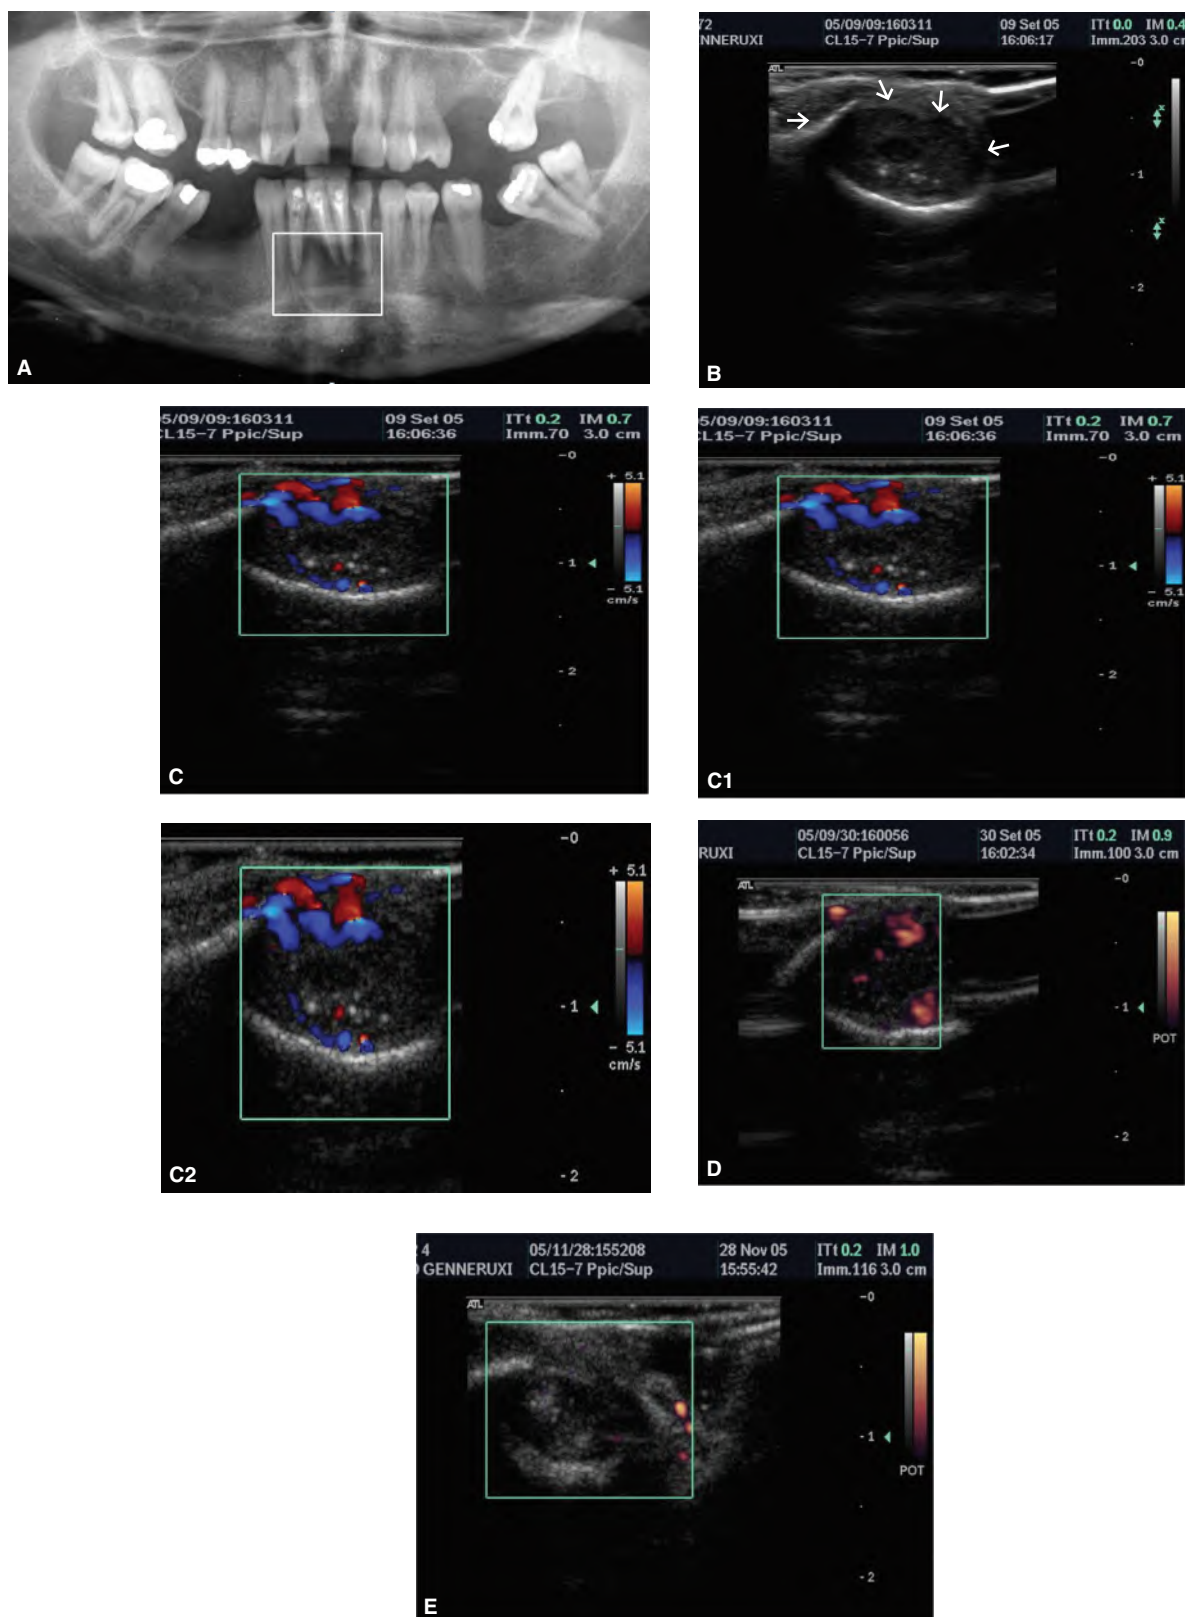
9 Ultrasound real-time imaging follow-up of an endodontic treatment with application of CPD. A. Panoramic radiograph showing an extensive periapical lesion involving all four mandibular incisors, before endodontic re-treatment (framed). B. The same lesion seen in the ultrasound image (arrows); it is an “echogenic” image with solid content and well-defined contours. C. The two echographic images of the same lesion after the application of the power Doppler (C1) and Color Doppler (C2) showing the presence of vascular supply. The diagnosis was periapical granuloma. D. Echography of the lesion (framed) one week after endodontic re-treatment was initiated and an intracanal medication was placed. The CPD shows reduced vascularization. E. Ultrasound image of the lesion (framed) one month after completion of retreatment on all four teeth. The CPD indicated that the vascular supply was greatly reduced.
